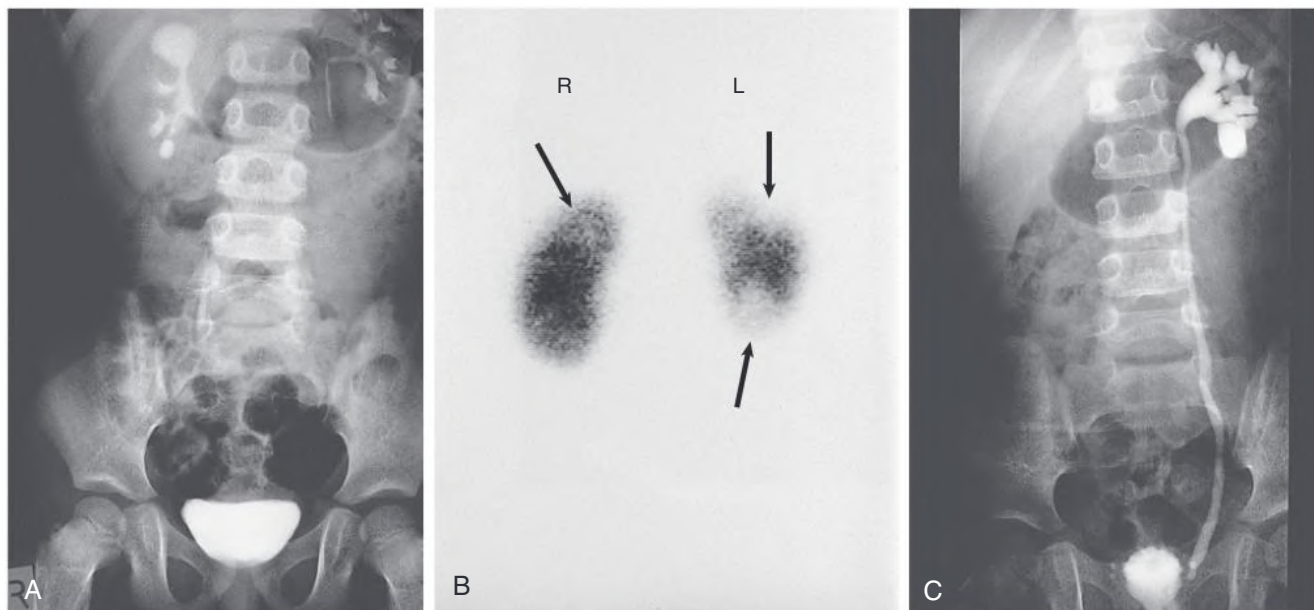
Investigation of Reflux Nephropathy in a 3-Year-Old Child With Urinary Tract Infection. (A) Intravenous urogram showing calyceal diverticulum in the upper pole of the right kidney and kidney scarring in the upper pole and, probably, the lower pole of the left kidney. (B) Dimercaptosuccinic acid scintigraphy (posterior view) demonstrating upper and lower pole scarring (arrows) in the left kidney and scarring of the right upper kidney in association with the calyceal diverticulum (arrowhead). (C) Voiding cystourethrogram showing grade IV vesicoureteral reflux on the left.
